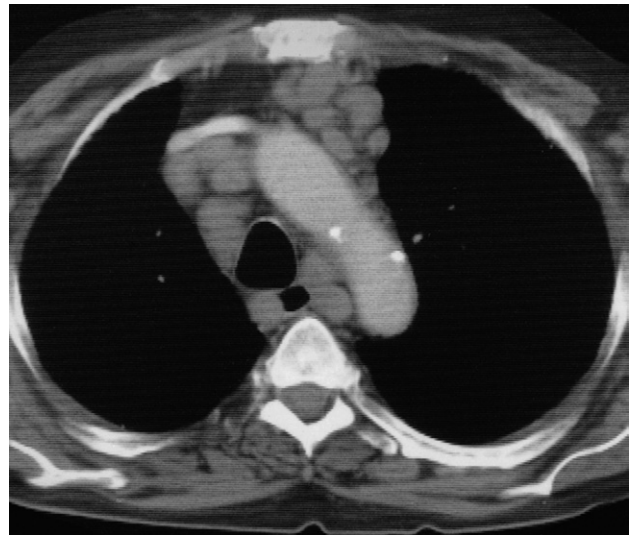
Extensive mediastinal lymphadenopathy (caused by lymphoma) shown by CT.
